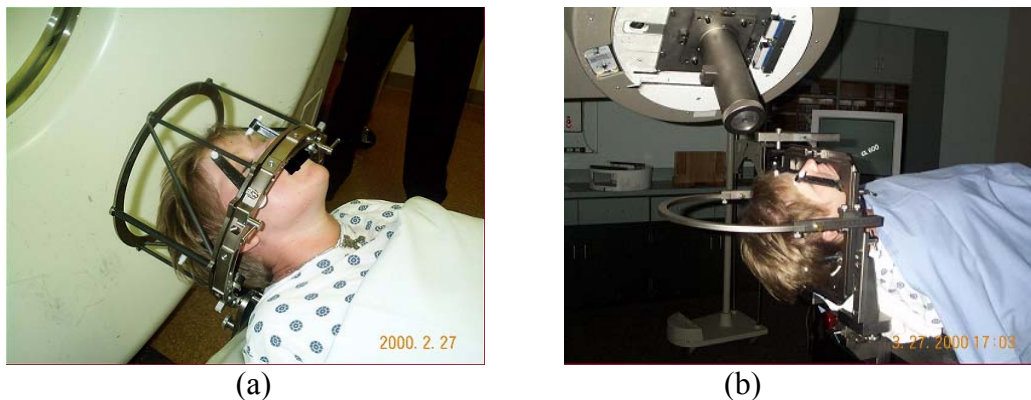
(a) CT stereotactic localizer attached to invasive head ring. Radio-opaque rods along the localization box define the stereotactic coordinate system in the treatment planning system. (b) Invasive stereotactic head ring. The head ring is rigidly attached to the patient's head and mounted to the treatment couch.
